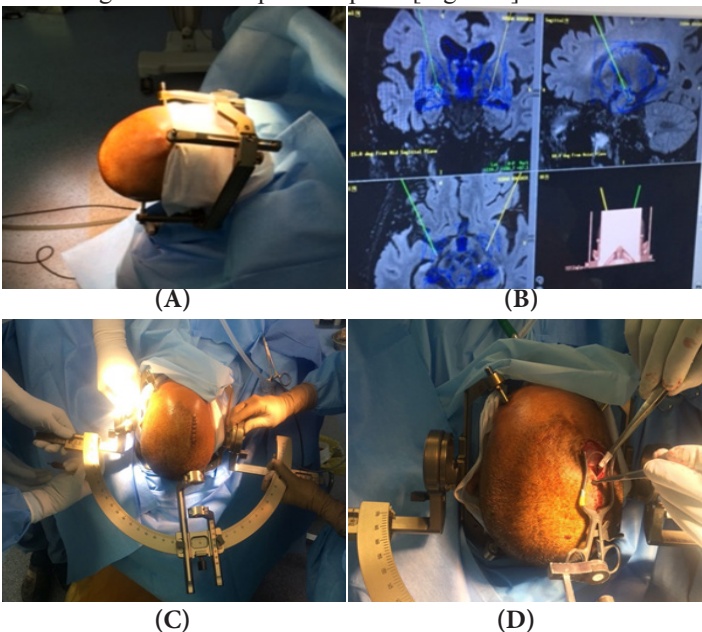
PREPARATION: The patient with the frame are shifted to the OT in [A], the MRI positioning system decides the location of the Burrholes in [B], the frame accessories are attached in [C]
